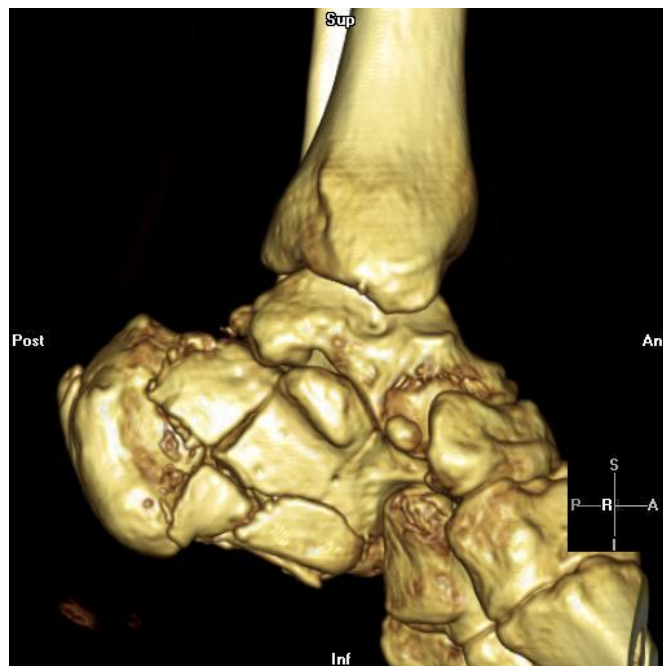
CT, left ankle, 3D color movie image revealing complex, comminuted calcaneal fracture.
